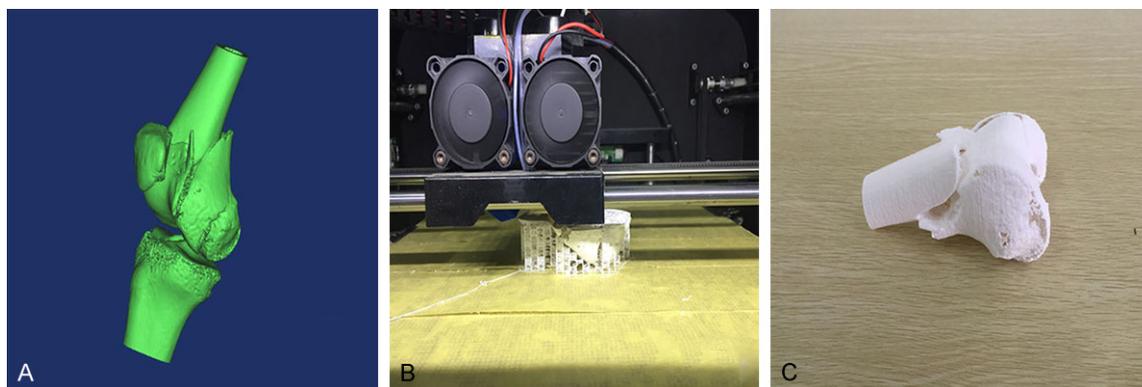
Three-dimensional printing process. A: Patient's CT data transferred to Mimics software to reconstruct fracture. B: 3D printing machine processing print fracture model. C: 3D printing fracture model.
